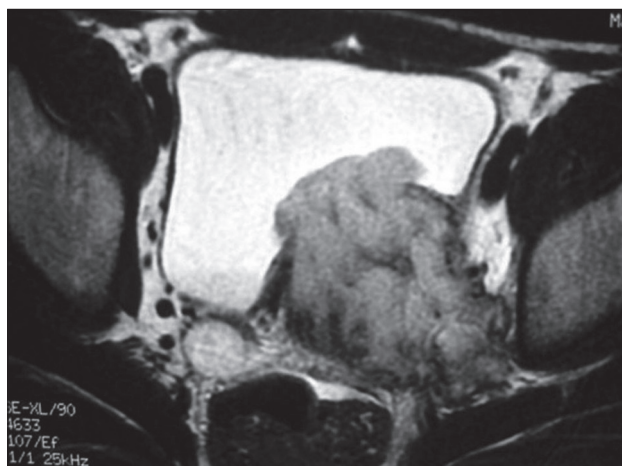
MRI demonstrating a large mass infiltrating the bladder wall.
